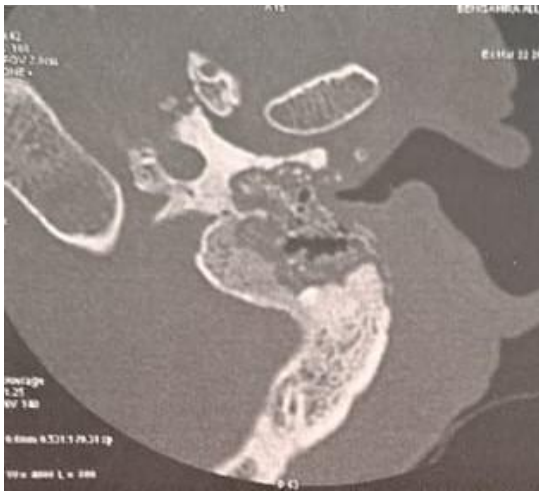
axial CT section showing lysis of the mastoid with signs of cholesteatomatous otitis
